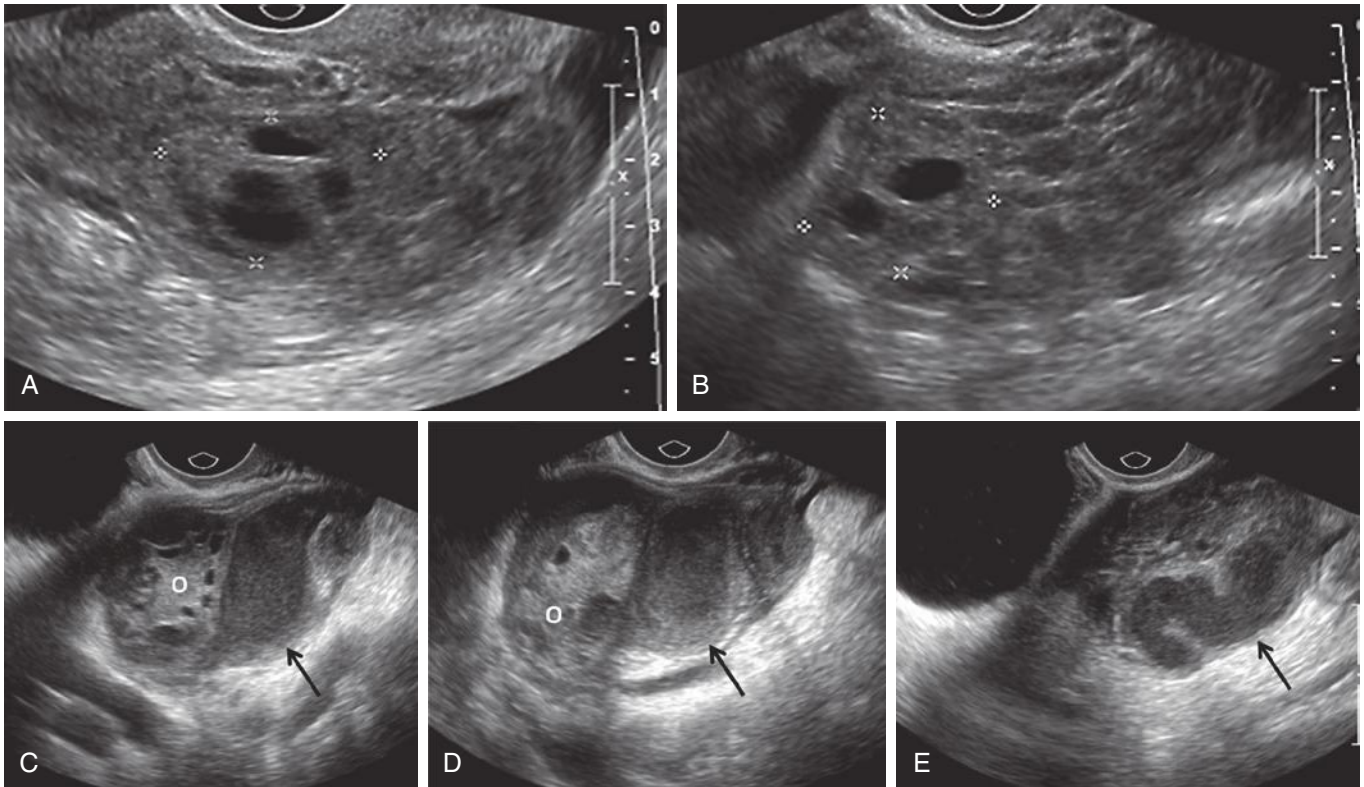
Tubo-ovarian complex. Transverse (A) and sagittal (B) images demonstrating a complex adnexal mass in a patient presenting with pelvic pain and fever. Note that the ovary (*calipers*) is recognizable and is surrounded by complex inflammatory material suggesting tubo-ovarian complex (TOC) rather than tubo-ovarian abscess (TOA). Sagittal (C and D) and transverse (E) gray-scale images in another patient presenting with pelvic pain and leukocytosis. The ovary (O) is recognizable with its small follicles but is surrounded by the dilated, pus-filled fallopian tube (pyosalpinx) (*arrows*) and complex fluid consistent with TOC. Note increased echogenicity of the adjacent pelvic fat, suggestive of inflammation or infection. (C, D, and E courtesy of Dr. Margarita Revzin, Yale University School of Medicine, New Haven, CT.)
